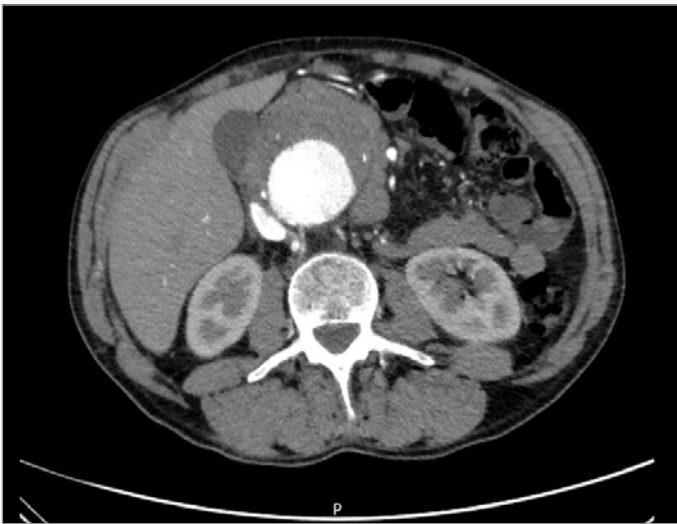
Abdominal aortic aneurysm in axial CT scan.
